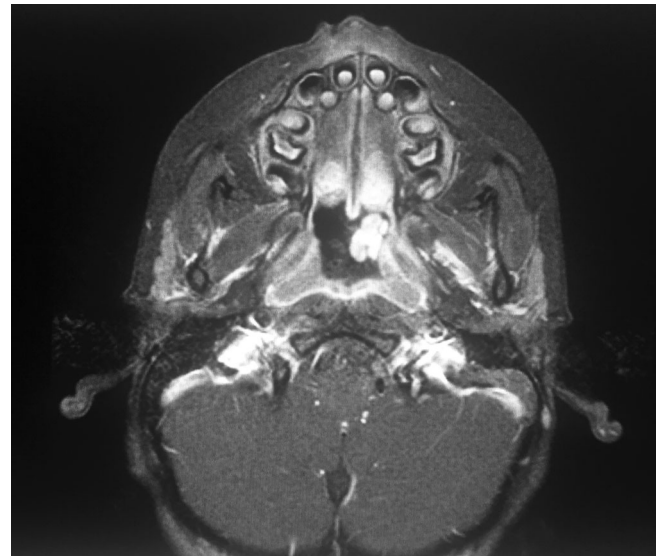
Post-operative axial magnetic resonance imaging demonstrating extensive soft-tissue density mass arising in the nasopharynx.
